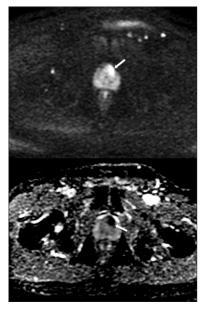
DWI (top) and ADC map (bottom) – Focal area within the anterior gland on the left showing high signal on DWI and corresponding low signal on ADC.
